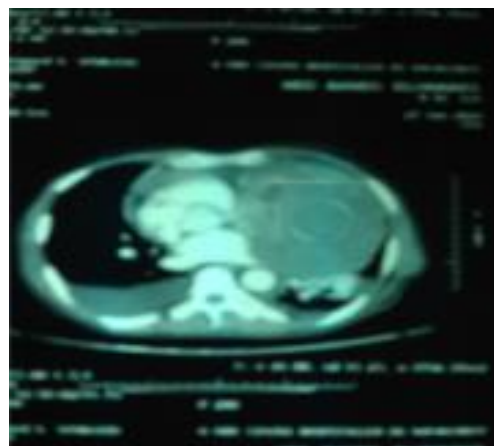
Thoracic CT angiography showing a mediastinal mass compressing the left cardiac chambers.
